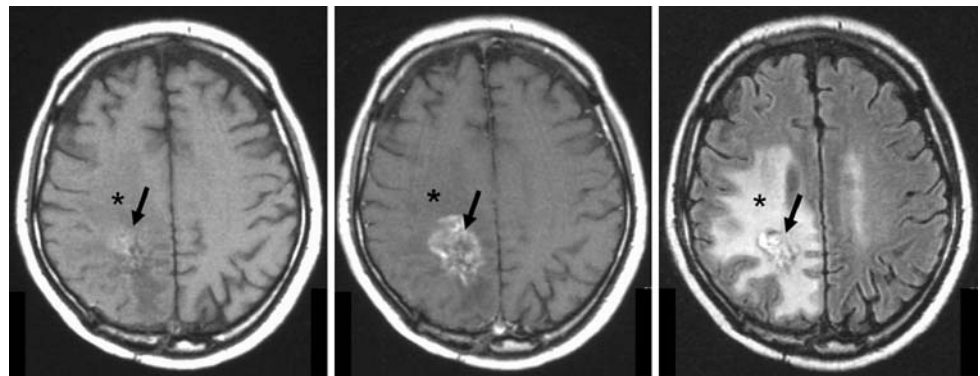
Thirty nine year old man after irradiation of a glioblastoma in the right parietal lobe (patient 3). Axial T1w, contrast-enhanced T1w, and FLAIR images are presented from left to right. A star-shaped, hemorrhagic, contrast-enhancing lesion (arrow) and a large edema (asterisk), consistent with a radiation injury, can be appreciated in the right parietal lobe
